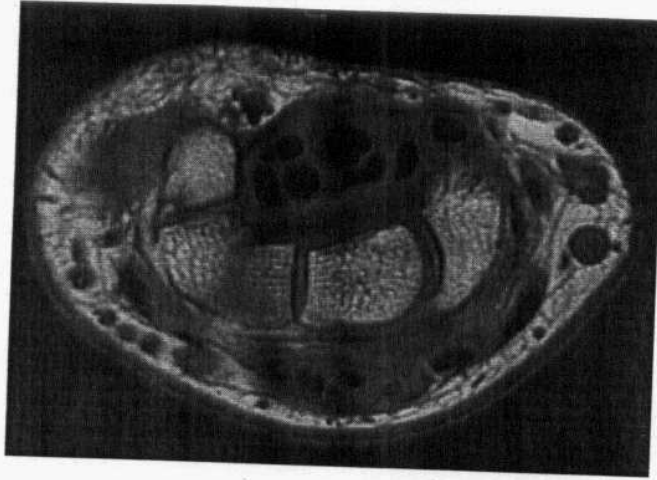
T2-weighted axial MRI at the level of the carpal bones show scaphoid, capitate, hamate, triquetrum, pisiform, radial artery, ulnar artery, flexor carpi radialis tendon, flexor carpi ulnaris, flexor digitorum superficialis tendons, flexor digitorum profundus tendons, flexor pollicis longus tendon, median nerve, extensor carpi radialis longus tendon, extensor carpi radialis brevis tendon, extensor pollicis longus tendon, extensor carpi ulnaris tendon & extensor tendons to digits 2-5 (Quoted from Nadja Saupe, et al.,2005).
